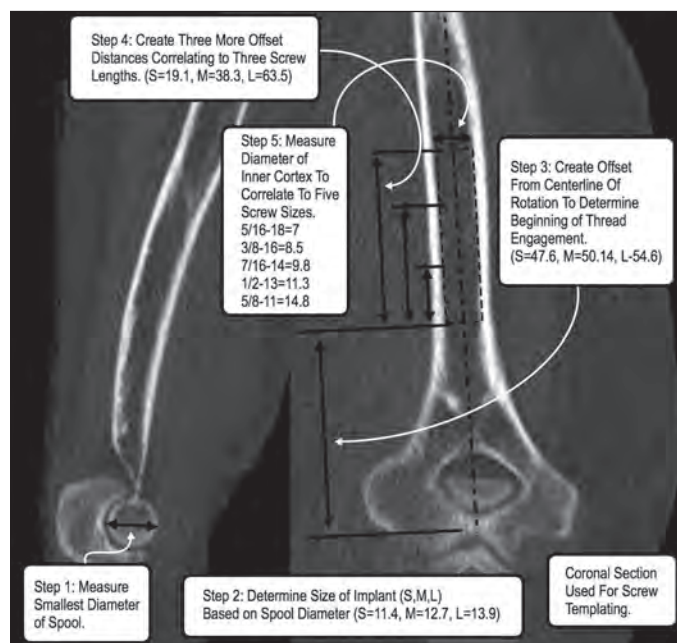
Algorithm for computed tomography scan–based templating of humeral screws
